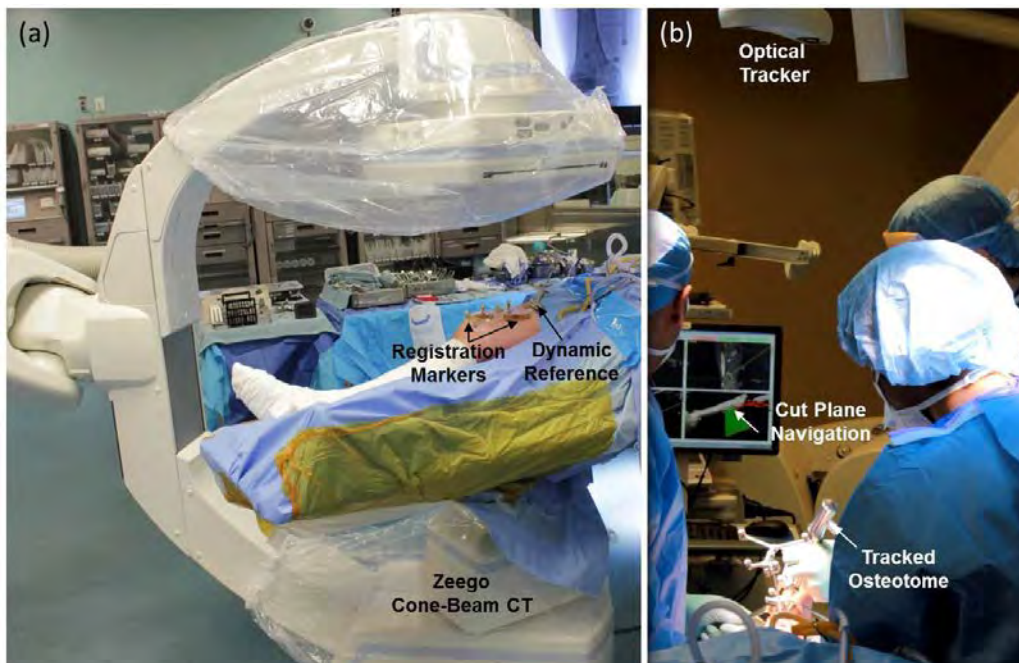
Setup showing the registration tools in the CT field of view with the overhead infrared camera capturing its spatial coordinates
